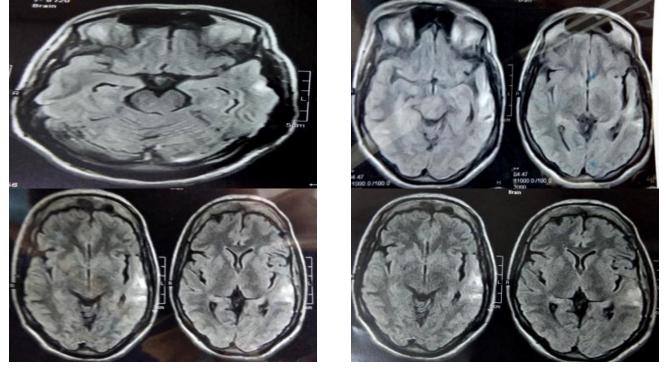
Post operative follow up 3 and 5 years after surgery enhanced MRI brain with no evidence of tumor residual or recurrence
